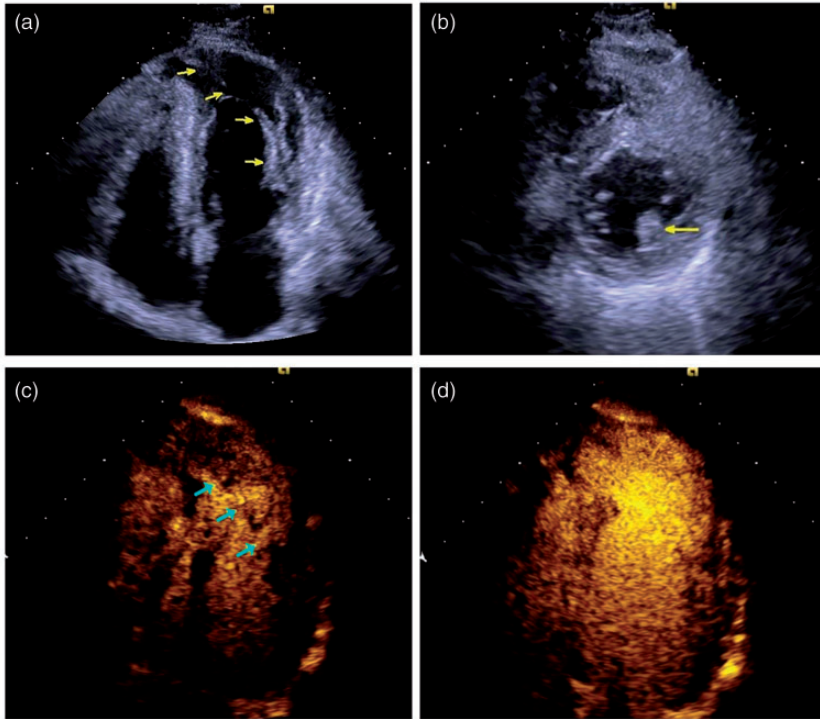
Echocardiogram of a double-chambered left ventricle. (a) In the apical four-chamber view, a large muscle bundle (arrows) divides the left ventricle into two chambers, with the upper chamber as the primary chamber and the lower chamber as the secondary chamber. The mitral valve and the aortic valve are located in the primary chamber. (b) Short-axis view of the left ventricle shows thickened anterolateral papillary muscles (arrow). (c) Apical four-chamber view of contrast-enhanced echocardiography of the left ventricle shows that the primary and secondary chambers are connected by multiple transportation channels (arrows). (d) Apical four-chamber view of contrast-enhanced echocardiography of the left ventricle shows that the left ventricular apical myocardium is thin, but myocardial perfusion is good.
